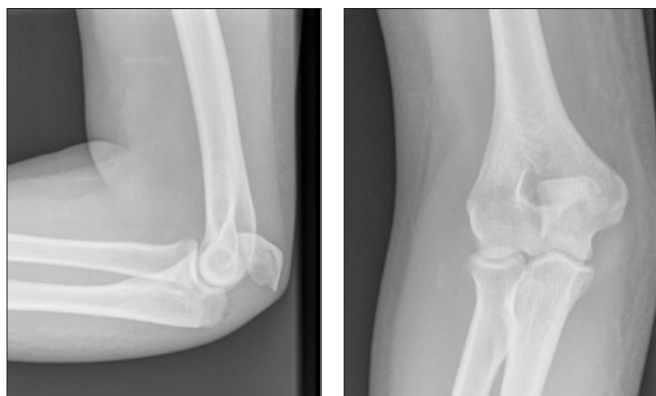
AP/ Lateral radiographs of the elbow showing a simple transverse fracture of the olecranon.
